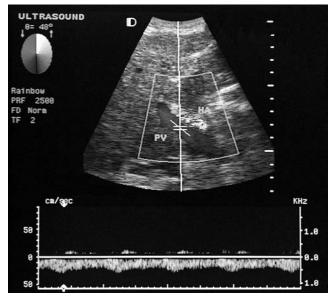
Duplex sonogram of the main portal vein.
